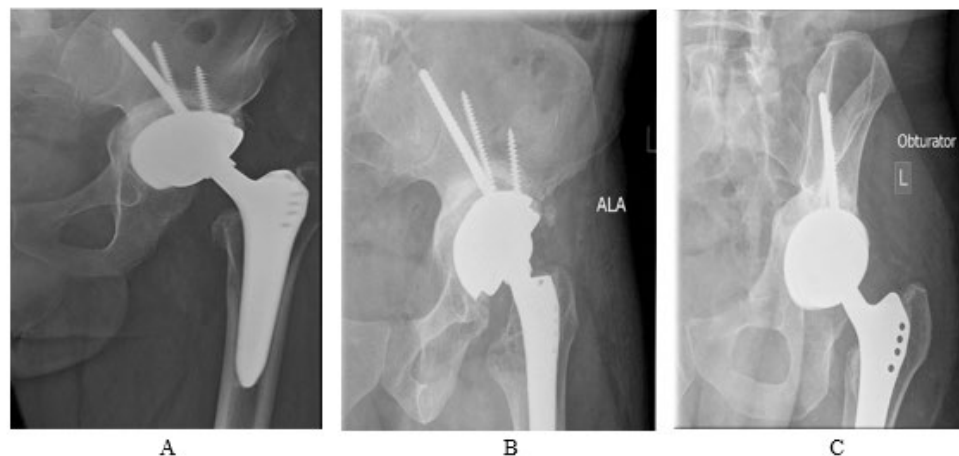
Radiographs of the left hip after revision, showing screw placement in the ilium. a, Anteroposterior view; b, ala radiograph of the ilium; c, obturator radiograph.
